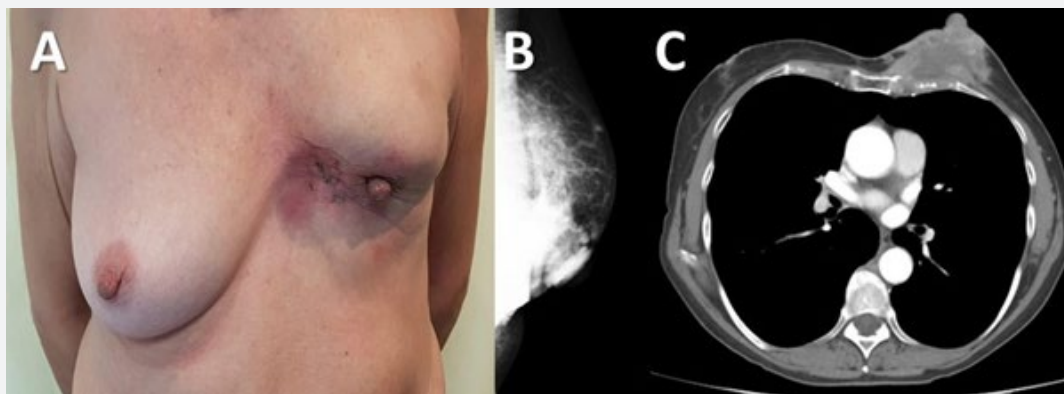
(A) Mass of hard consistency with skin retraction and a post-chemotherapy healed ulcer. Mammography (B) and Thoracic CT scan (C) show multinodular mammary mass involvement of pectoral and intercostal musculature and multiple adenopathies with retraction and thickened of NAC.
